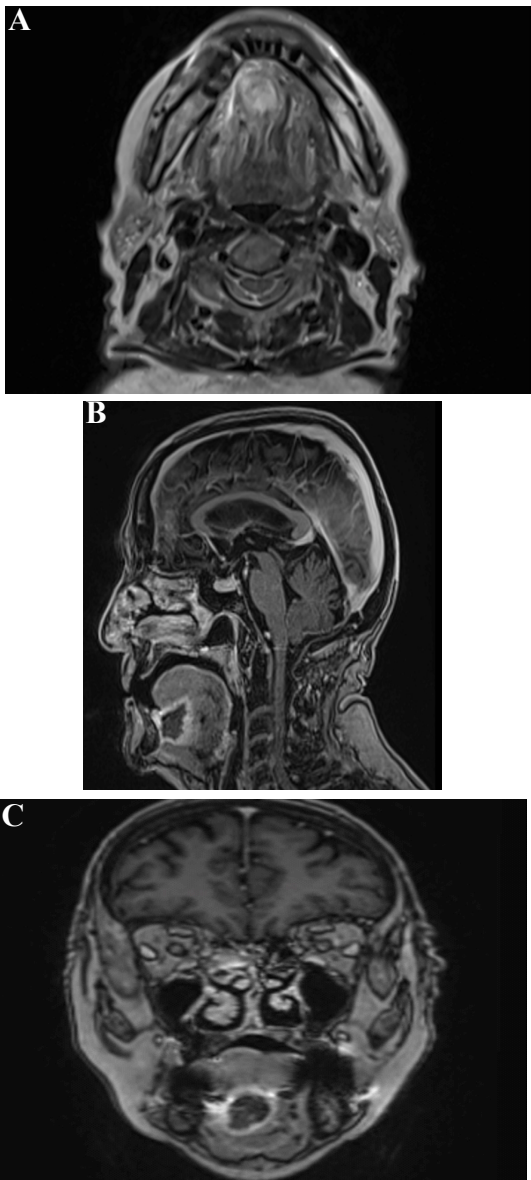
axial (A), sagittal (B) and coronal (C) cuts of an MRI showing a necrotic lesion with peripheral captation of contrast in the interior portion of the mobile tongue, affecting the floor of the mouth, suggesting tumoral infiltration.
